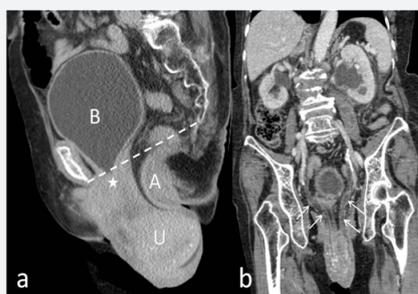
(a) Mid-sagittal reconstruction image of the contrast-enhanced CT scan shows prolapse of the uterus (U). The bladder neck (white asterisk) reveals beaking appearance and descends below the pubococcygeal line (white dash line). A = anal canal.
